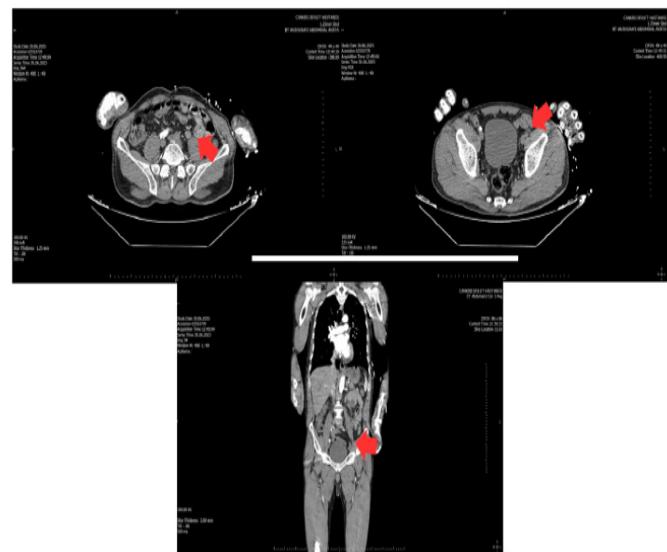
Transverse and coronal images from thoracoabdominal computed tomographic angiography demonstrating iliac occlusion from different angles
